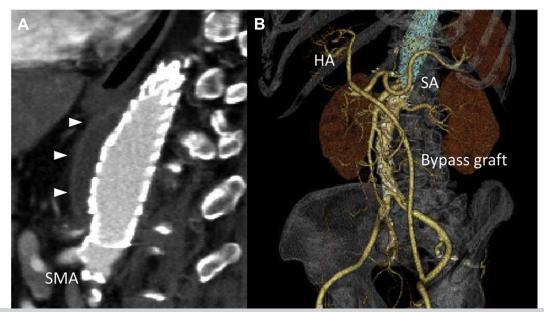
Postoperative contrast-enhanced computed tomography (CT) scan. A, There is no sign of endoleak at ruptured site (*arrowheads*). B, Three-dimensional image demonstrates patent graft and celiac artery (CA) branches. *HA*, Hepatic artery; *SA*, splenic artery; *SMA*, superior mesenteric artery.
